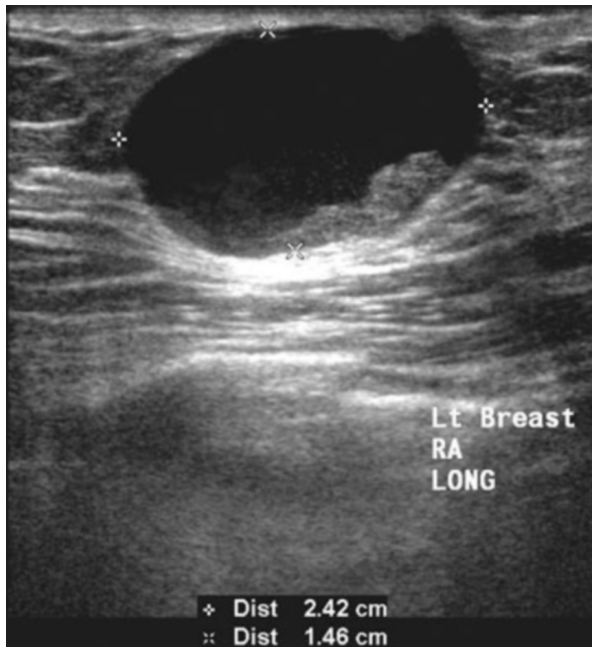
70-year-old man with intracystic papillary carcinoma. At presentation, long-axis sonogram of left breast mass demonstrated a complex mass with a solid nodular component.
